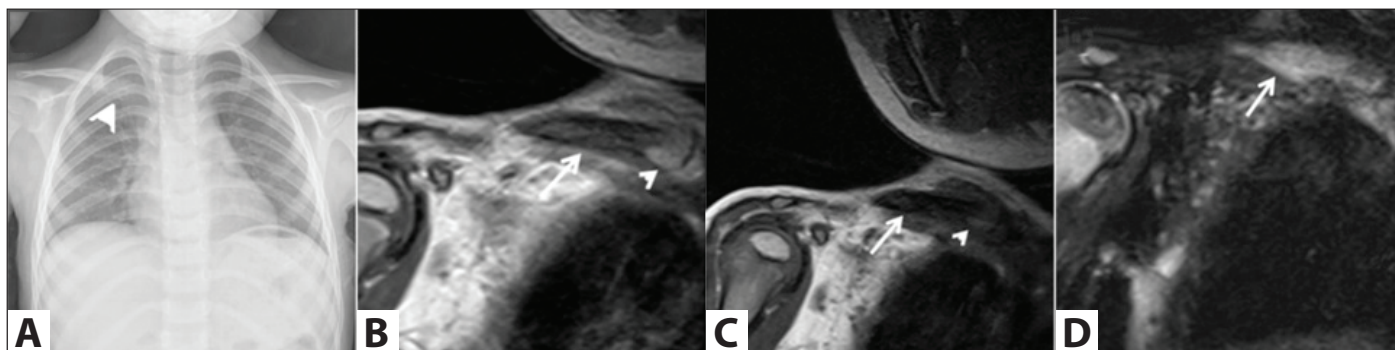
A. Lytic and sclerotic lesion on the right clavicle on X-ray (arrowhead). B. Coronal T2 weighted fat saturated image demonstrates medullary edema of clavicle (arrow). C. Coronal T1 weighted image obtained before administration of contrast material demonstrates hypointensity (arrow) in the medulla of clavicle related to sclerosis as well as increased soft tissue intensity (arrowhead) and capsular distension of sternoclavicular joint. D. Coronal T1 weighted image obtained after administration of contrast material demonstrates marked enhancement of the medulla (arrow) and joint (arrowhead) secondary to inflammation.
